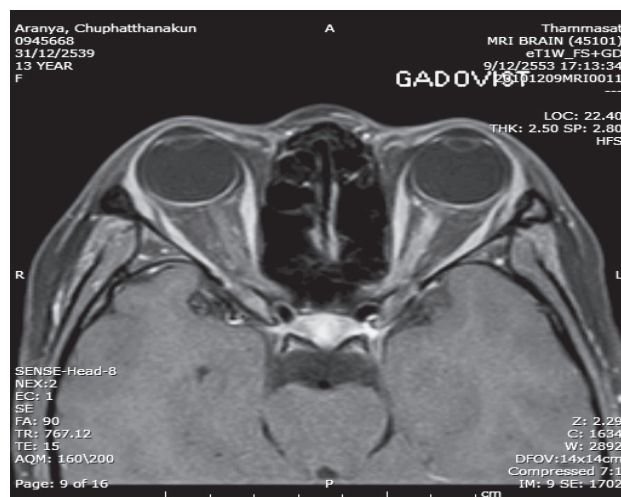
shows gadolinium-enhancing left optic nerve lesions in fat-suppressed T1-weighted orbital MRI.
